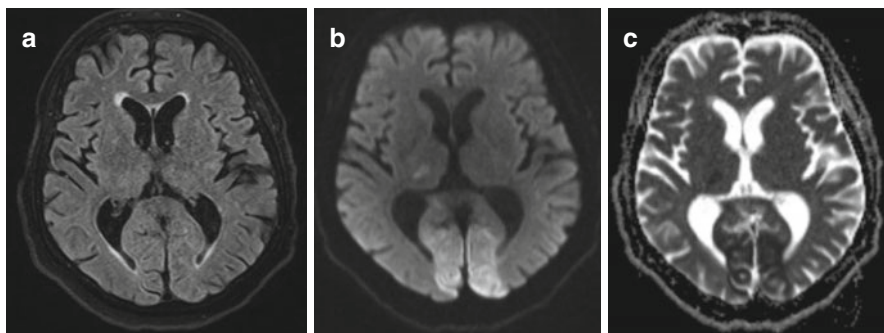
Hyperacute stroke of the posterior circulation. The FLAIR image (a) shows no pathological changes. Diffusion-weighted MR image (b) shows areas of increased signal intensity in the right thalamus and bilateral occipital lobes. The ADC map (c) confirms the restriction in diffusion typical of infarction
